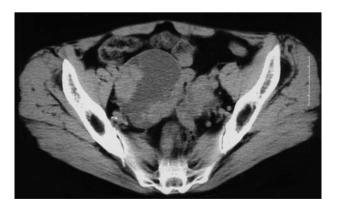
Computed tomography (CT) confirms the echographic findings and shows irregularity of the cyst wall. No calcifications, ascites or lymph node invasion are visible
